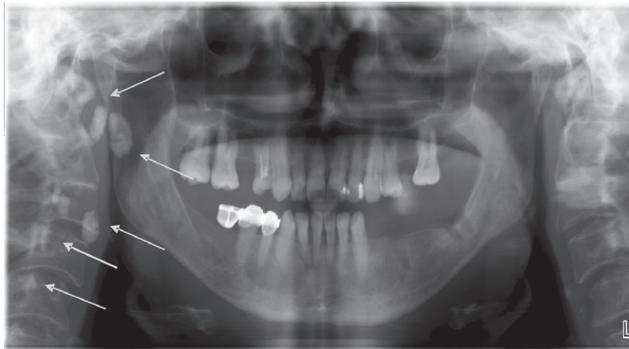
Radiopaque masses on panoramic radiograph.
